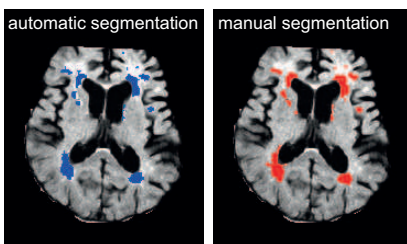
FLAIR-overlaid WMH automatic segmentation using a cascade of reduced support vector machine algorithm. Note the accuracy of segmentation (comparable with manual segmentation). Courtesy of Soheil Damangir, Karolinska Institutet
